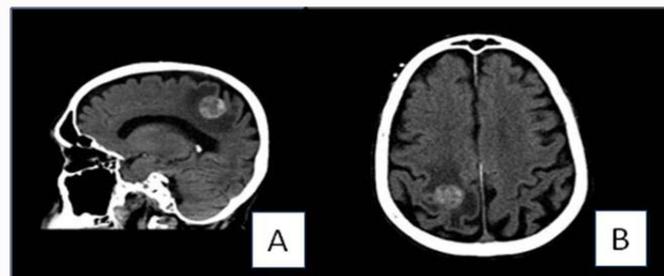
Sagittal (A) and axial (B) CT scan images showing a round subcortical parietal lesion.
